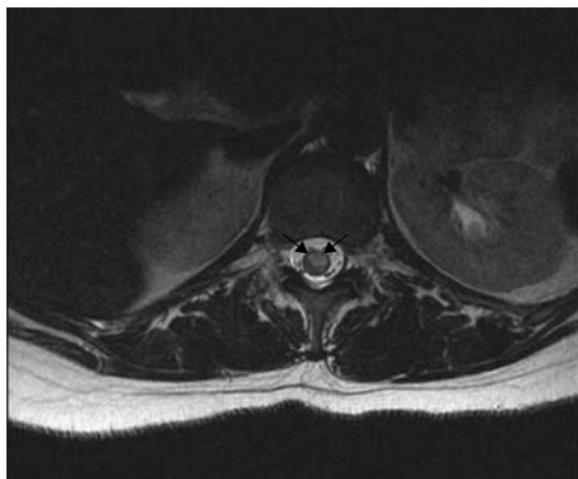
Lower spinal cord infarct. (a) Sagittal T2 weighted and (b) axial T2 weighted MRI. Subtle hyperintensity and expansion is demonstrated in the terminal spinal cord (closed white arrowheads). (b) Axial imaging reveals signal abnormality involving the anterior two-thirds of the cross-sectional profile of the spinal cord (black arrows), typical for an anterior spinal artery territory infarct.
